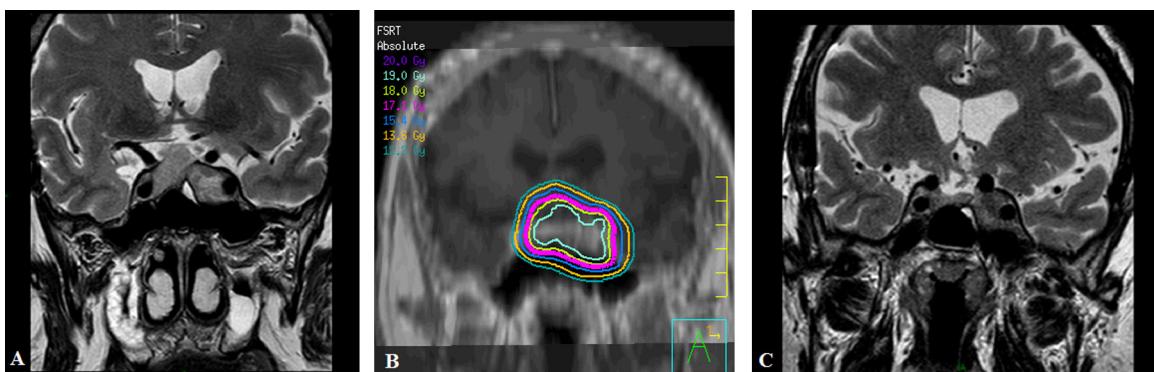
Pituitary adenoma in a 61 years old, male already treated with partial surgery. (A) MRI in coronal view showing a lesion extending to the parasellar region and abutting the chiasm. (B) Coronal view of the treatment plan showing the isodose distribution of FSRT to a total dose of 18Gy in 3 fractions of 6 Gy (prescribed to the 95% isodose). (C) MRI in coronal view 4 years after completion of FSRT.
